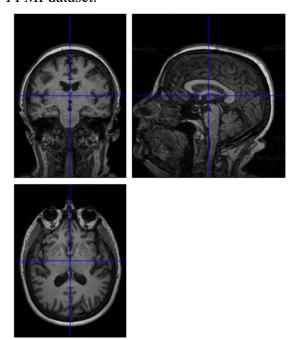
Whole brain MRI (coronal view - top left, sagittal view - top right, axial view - bottom left)
